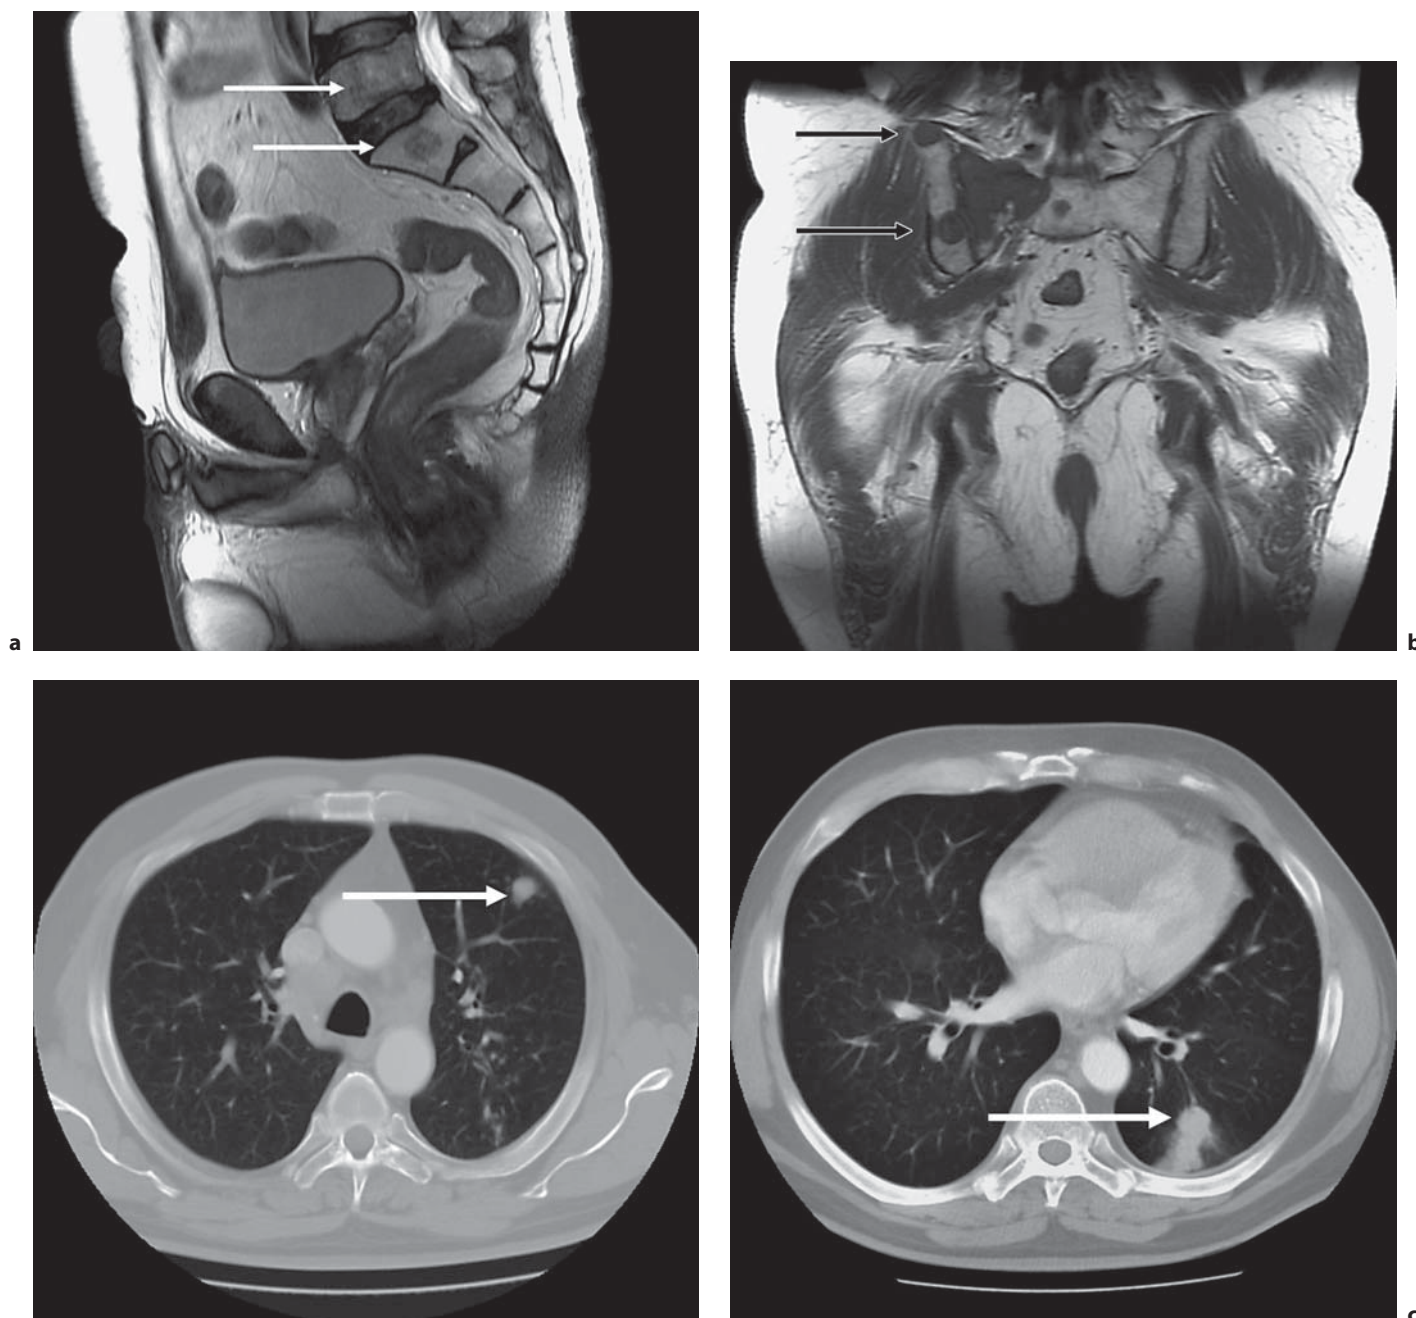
Male patient aged 52 years with a well-differentiated neuroendocrine carcinoma of unknown primary origin and metastases to liver, lung and bones. a MRI: demonstrating metastases to L₁ and L₅ vertebrae. b MRI: metastases to the right sacral bone, the iliac and pubic bone on the left iliac ala. c Thoracic CT scan: metastatic foci in the left lung (the largest measures 13 mm in diameter) and numerous enlarged mediastinal lymph nodes.
